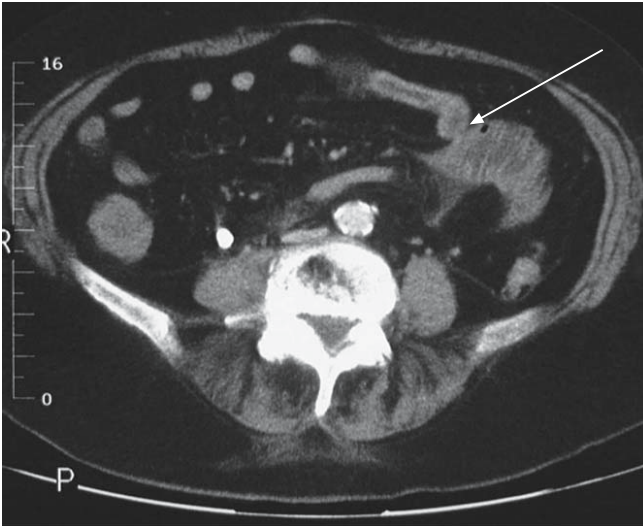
CT in a patient with small bowel obstruction showing the transition point between the distended proximal and collapsed distal bowel (*arrow*)
